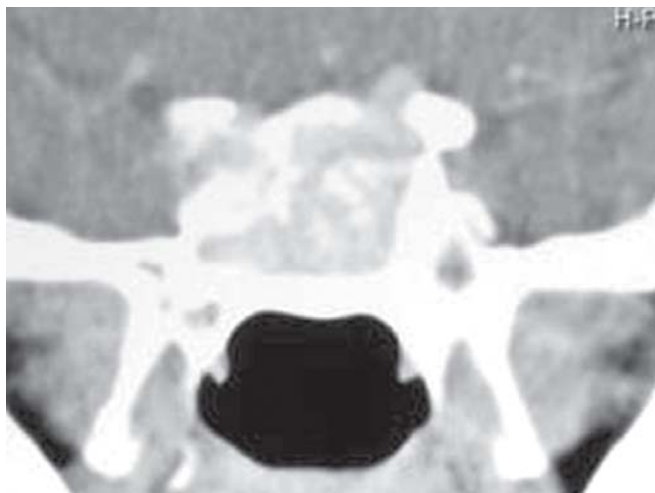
Coronal CT – PNS showing erosion of the roof of the left, and lateral wall of the right sphenoid sinus, in a case of bilateral AFRS
